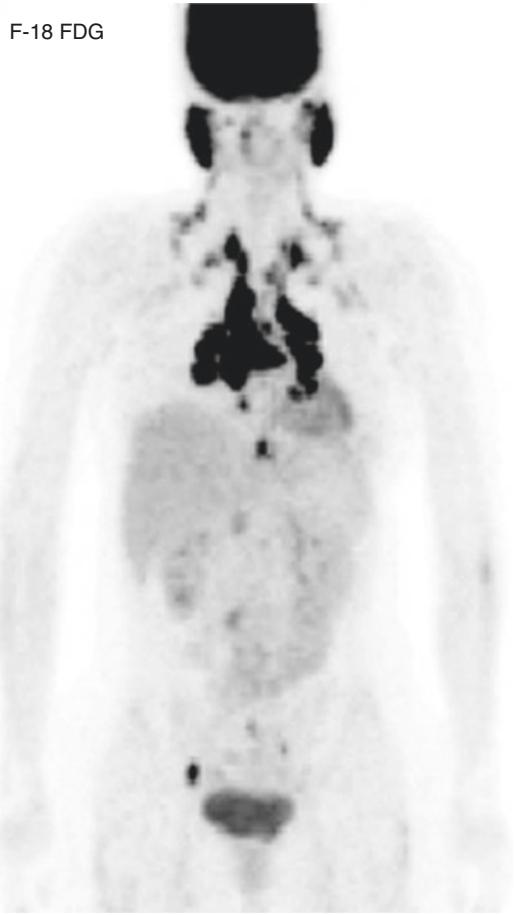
F-18 FDG image of a 35-year-old female with proven sarcoidosis. The study shows uptake in the areas of active inflammation in mediastinum, pulmonary hilus, salivary glands, and cervical, supraclavicular, axillary, para-aortic, iliac, and inguinal lymph nodes. (Courtesy of Professor Osama Sabry)
